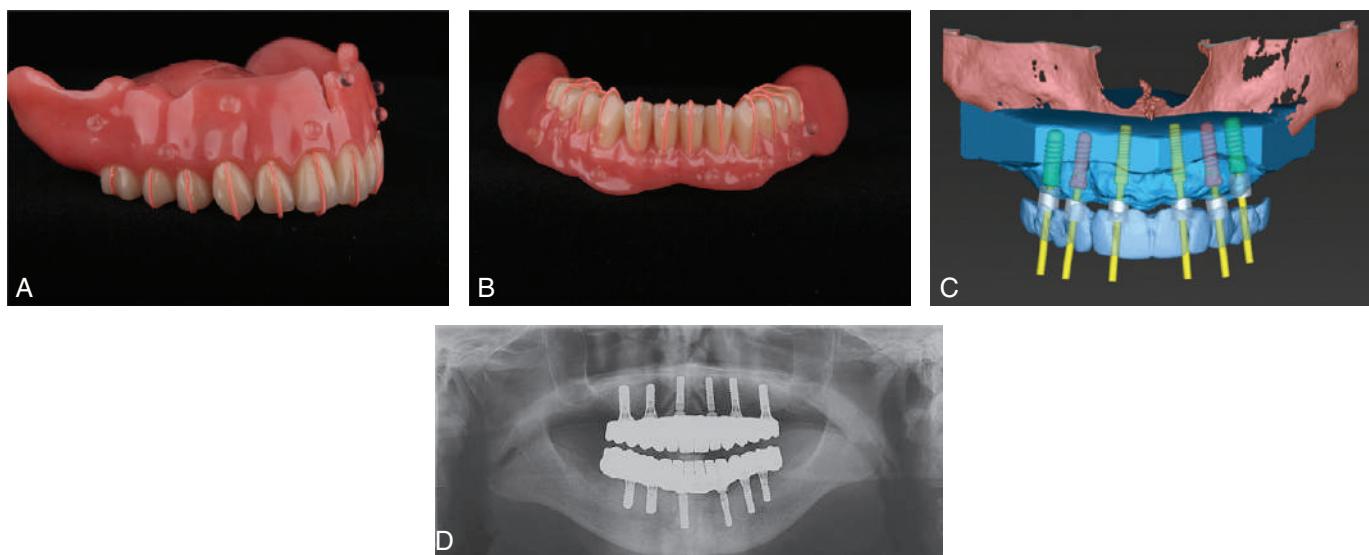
(A and B) Complete dentures with radiographic markers. (C) Complete denture is computed tomography scanned when in patient's mouth and implants are virtually placed considering the marker locations. (D) Panoramic radiograph showing implants placed according to the virtual plan. (A–D, Courtesy Dr. Manrique Fonseca.)
